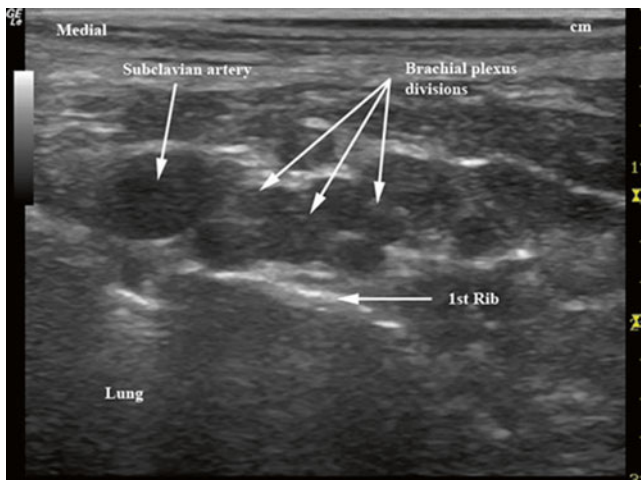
Brachial plexus divisions in the supraclavicular fossa with ultrasound (With permission from Buckenmaier and Bleckner [71])
